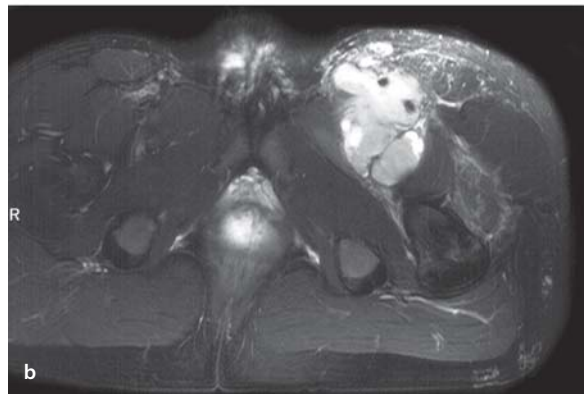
a,b. Synovial sarcoma in a 19-year-old man. a Computed tomography (CT) with intravenous contrast medium. b Axial T2-weighted, fast spin-echo image with fat suppression. Both show the tumor arising in the left groin with involvement of the femoral vessels, but the features are more conspicuous on the MR image (b)
